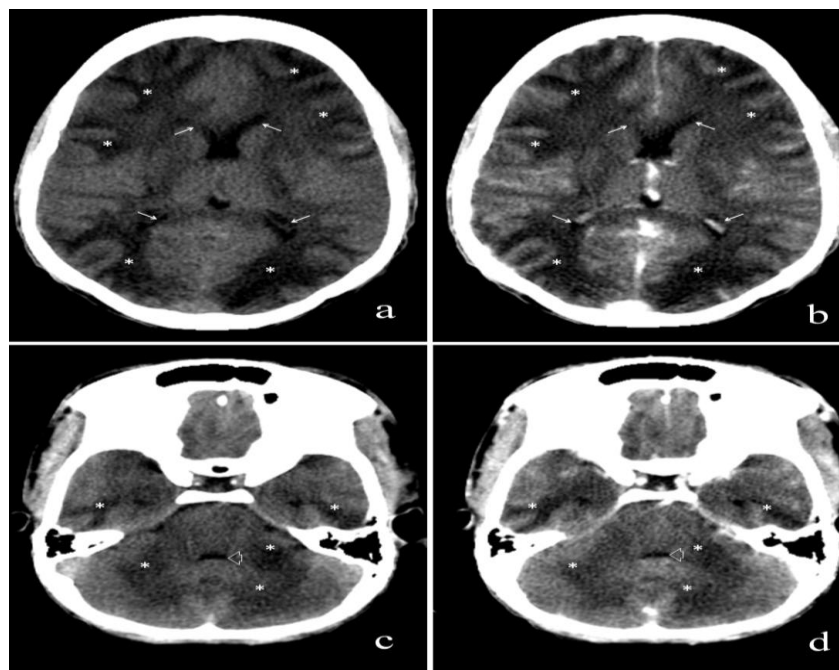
Pre-contrast and post-contrast axial brain CT scan images at the (a and b) ganglionic, and (c and d) pontine levels showing extensive bilateral symmetrical areas of primarily subcortical white matter hypodensity involving the cerebrum and cerebellum on both sides (*) with no demonstrable enhancement post intravenous contrast. Mild narrowing of the lateral ventricles (thin arrows) and fourth ventricle (thick arrows) is also noted. These findings are consistent with diffuse vasogenic edema with no associated parenchymal haemorrhage.
